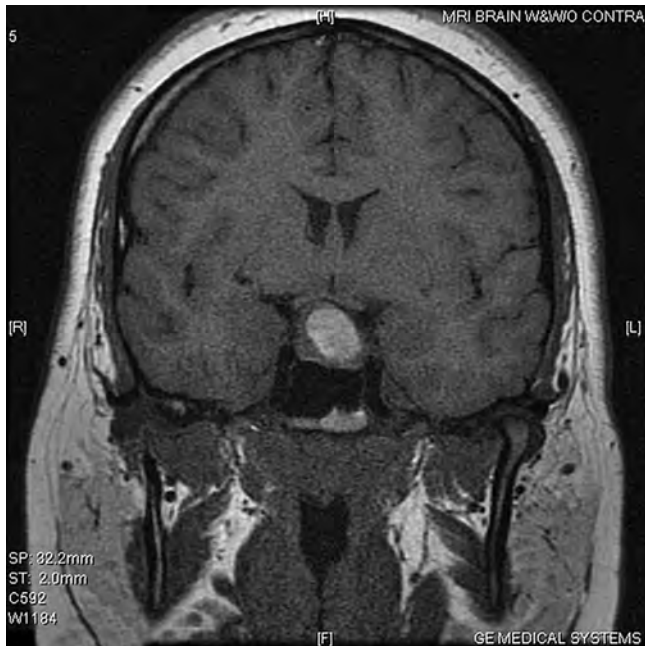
Large pituitary macroadenoma revealed by cranial magnetic resonance imaging.
